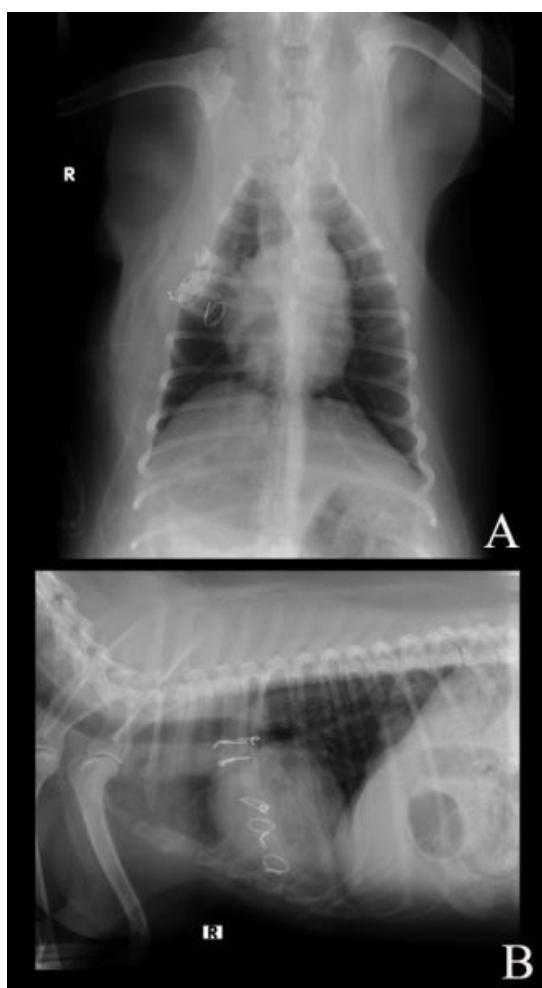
Ventro-dorsal (A) and lateral view (B) thoracic radiograph were performed prior to chest tube removal; there were no presenting of pneumomotorax or pleural effusion.
